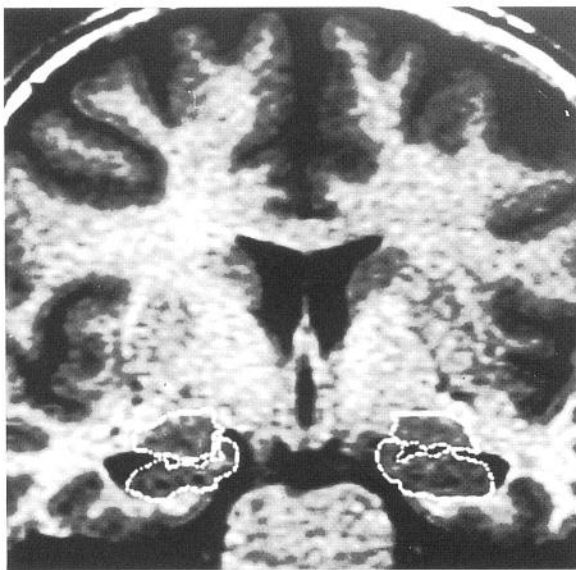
Coronal magnetic resonance imaging scan (Patient 5) passing through the heads of the hippocampi (lower structures outlined) showing mild right hippocampal atrophy (ratio = 0.85). Upper structures outlined are the amygdalae.
